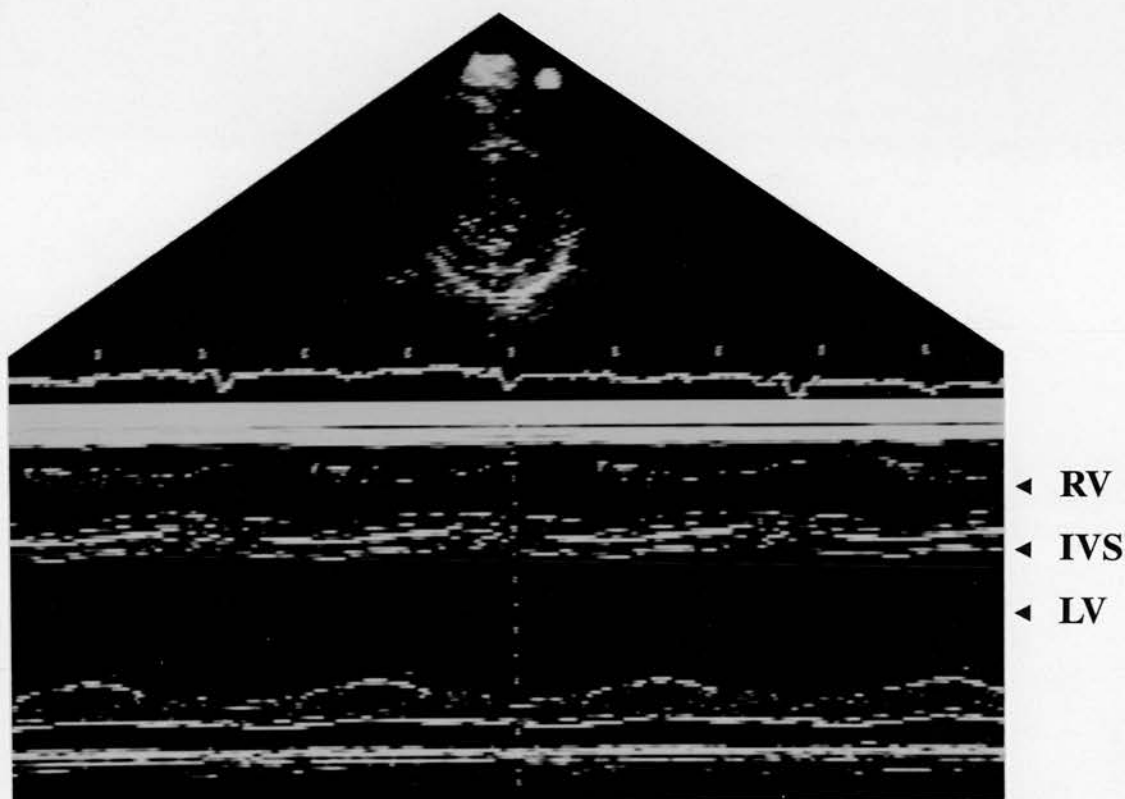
M-mode echocardiogram (short axis view) of a patient with dilated cardiomyopathy.
